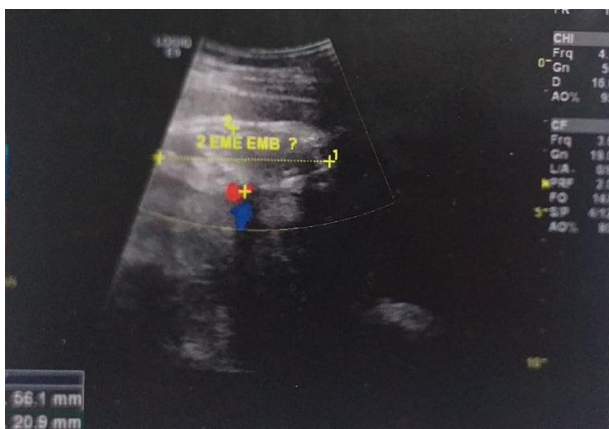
Ultrasound image showing evanescence of a twin in the first trimester.
